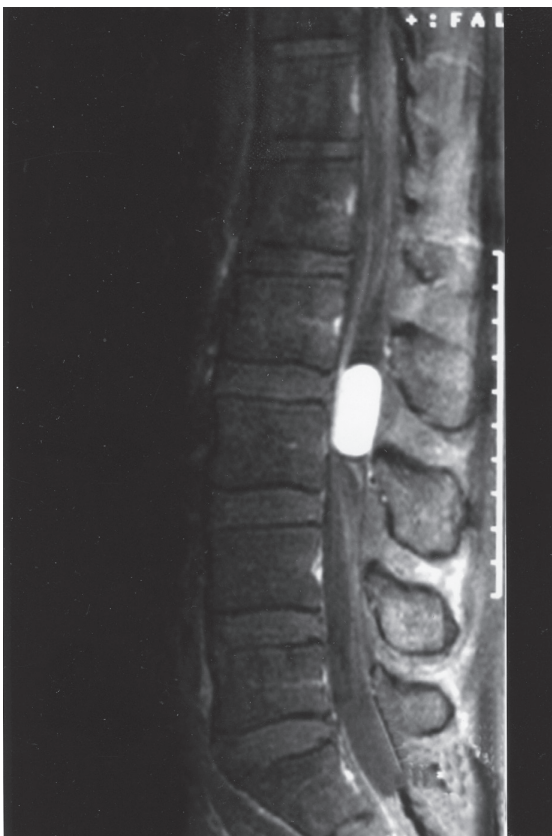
Preoperative contrast-enhanced T1-weighted lumbosacral MR imaging shows tumour at L2/3 interspace.
